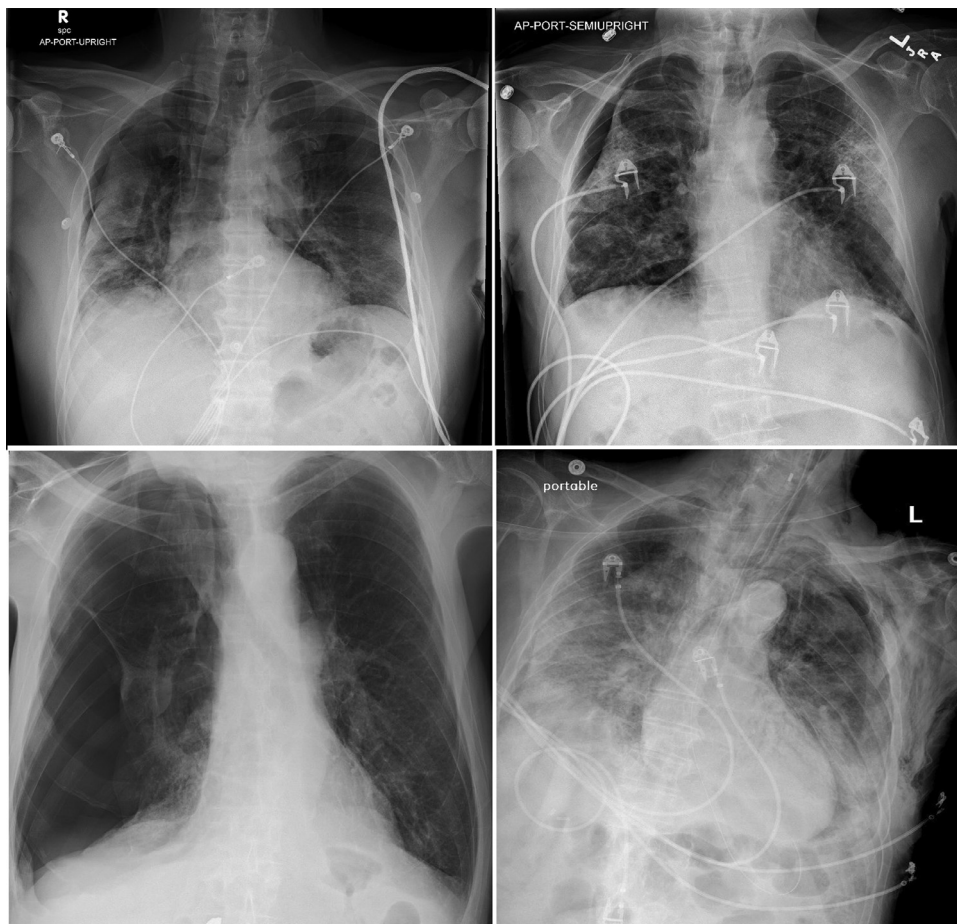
Chest x-rays of four patients demonstrating pneumothoraces.
